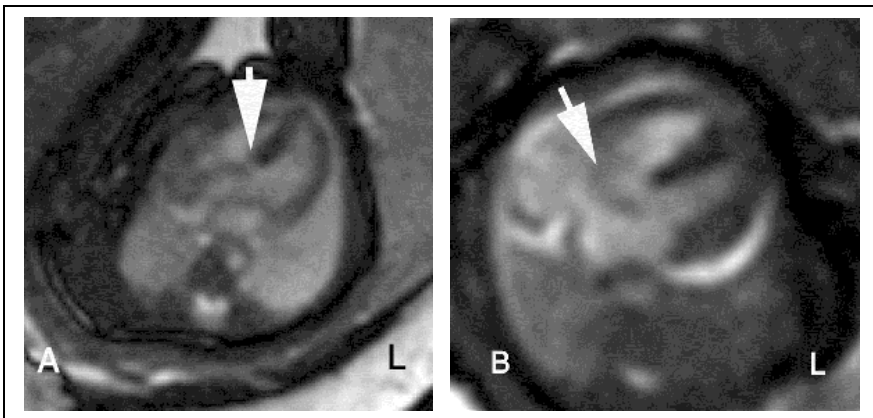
Interventricular septal defects are detected in four-chamber T2-SSFP fetal CMR. (A) In a 25 weeks' gestation fetus with Trisomy 13, MR image shows a small high interventricular septal defect (VSD). (B). In a 30 weeks' gestation fetus, MR image shows a large atrioventricular septal defect (AV canal) (arrow) as part of a complex cardiac anomaly in association with transposition of great arteries (TGA) (not shown).
